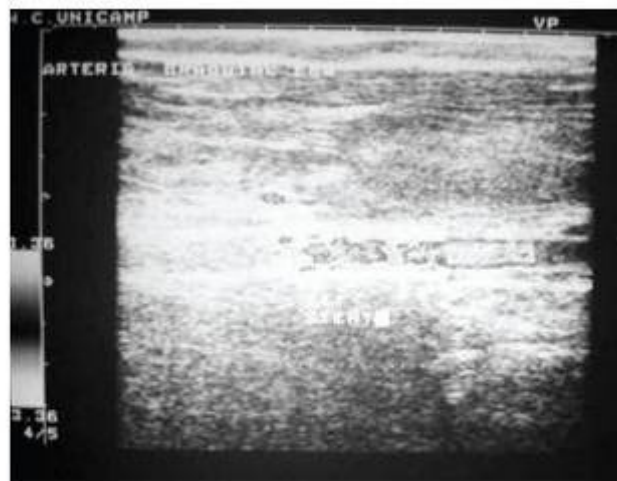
Doppler ultrasound showing flow after repair of case 3
